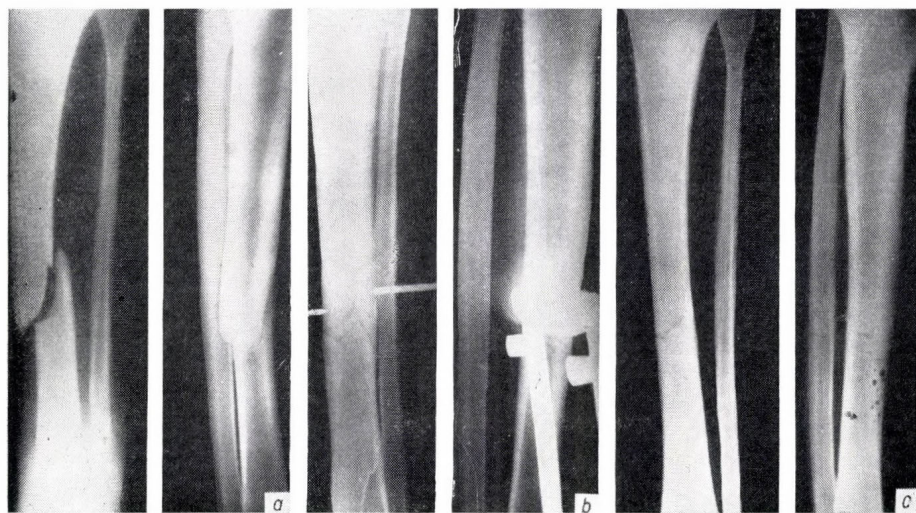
X-ray picture of leg fracture before (a) cortical fixation, after operation (b) and after removal of the plaster (c); minimal callus formation
